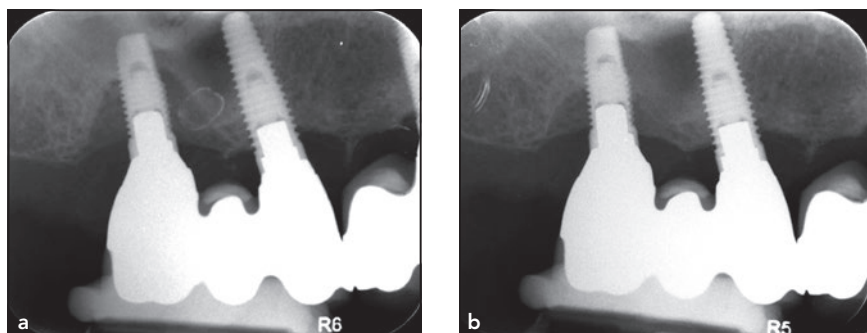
Laser-treated implant in the maxillary right first molar site. (a) Preoperative periapical radiograph. The patient was restored with a diastema to match her previous natural dentition. (b) Postoperative periapical radiograph. Bone gain of 3 to 4 mm was measured 1 year after laser therapy.
